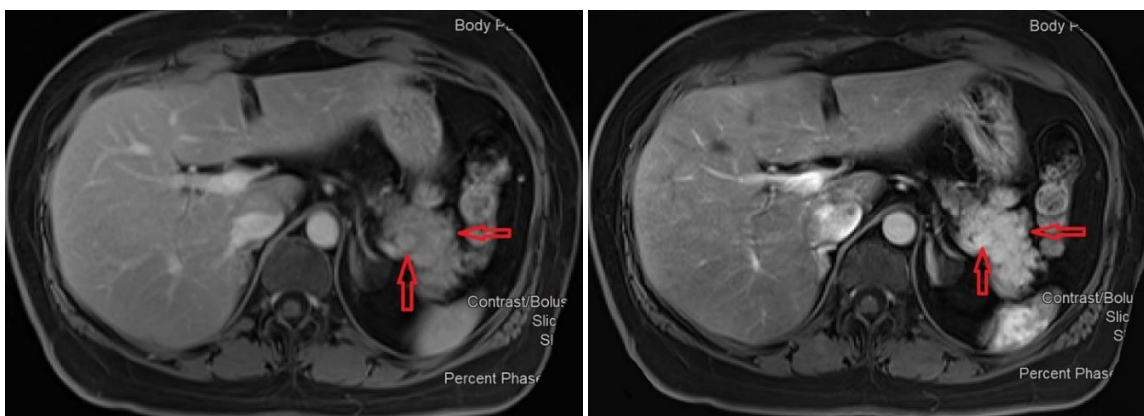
Contrast-enhanced MRI of the abdomen and pelvis with red arrows indicating the location of pancreatic tail lesions.
